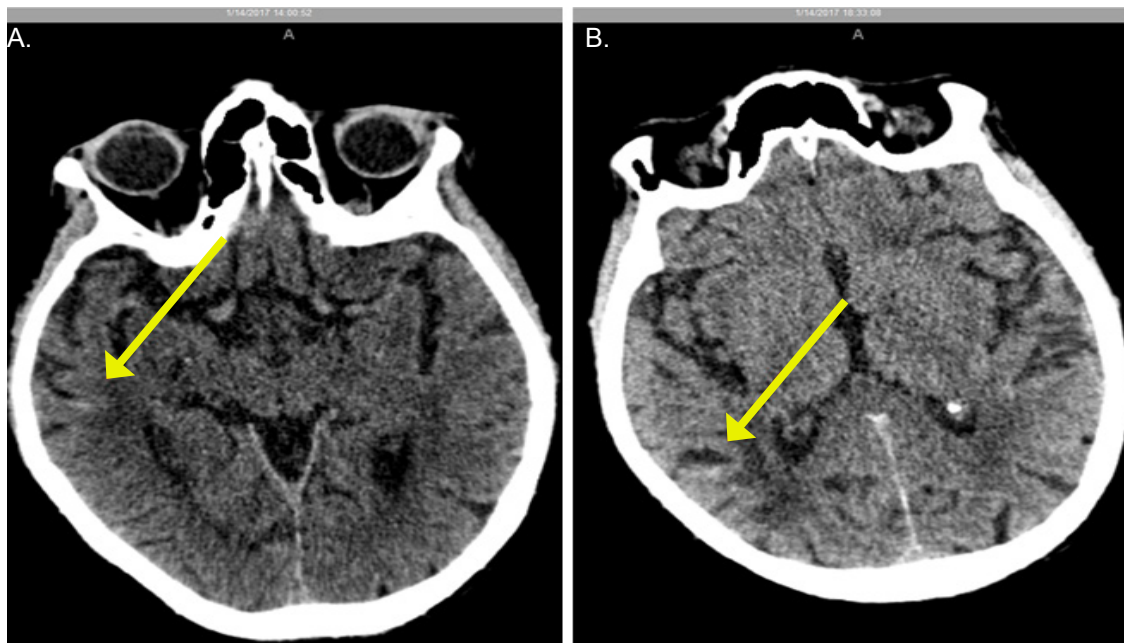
Axial computed tomography demonstrating trace blood (arrows) at presentation (A) and four hours later (B) showing no progression of bleeding.
